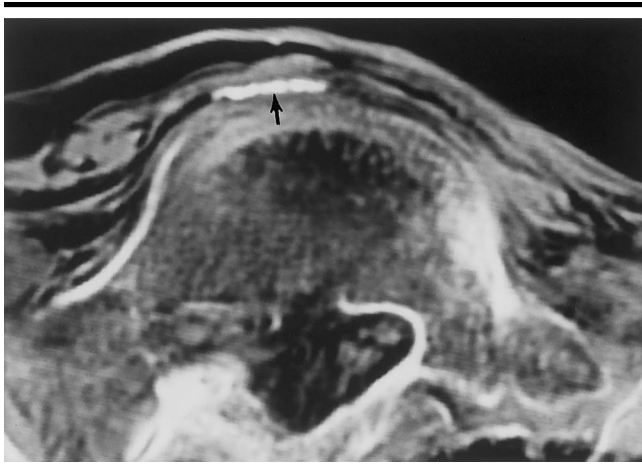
Transverse CT section through the lower abdomen (obtained on May 3, 1994) shows a linear calcification (arrow) closely juxtaposed to the anterior cortex of the transitional vertebral body. We interpreted this feature as calcification in the aorta, now collapsed following desiccation.
